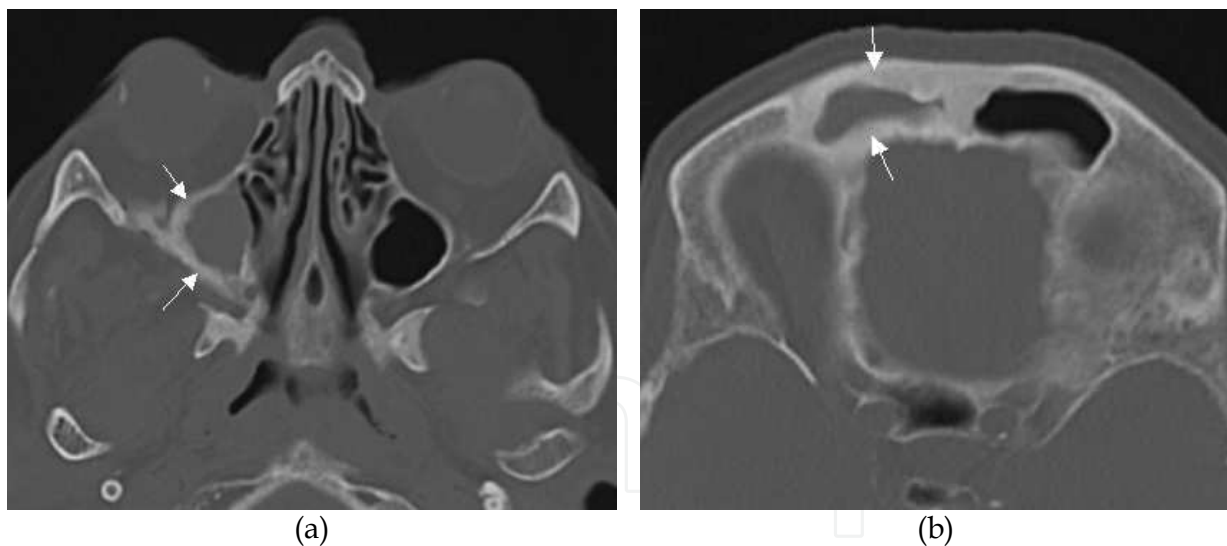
Axial CT showing total opacification of the maxillary (a) and the frontal (b) sinuses accompanied with sclerotic bone thickening (arrows) indicating a chronic infection.
